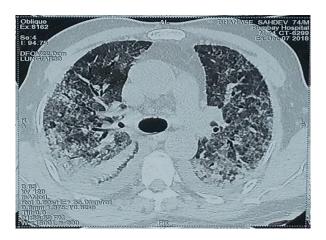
CT scan image 2 of the patient.
